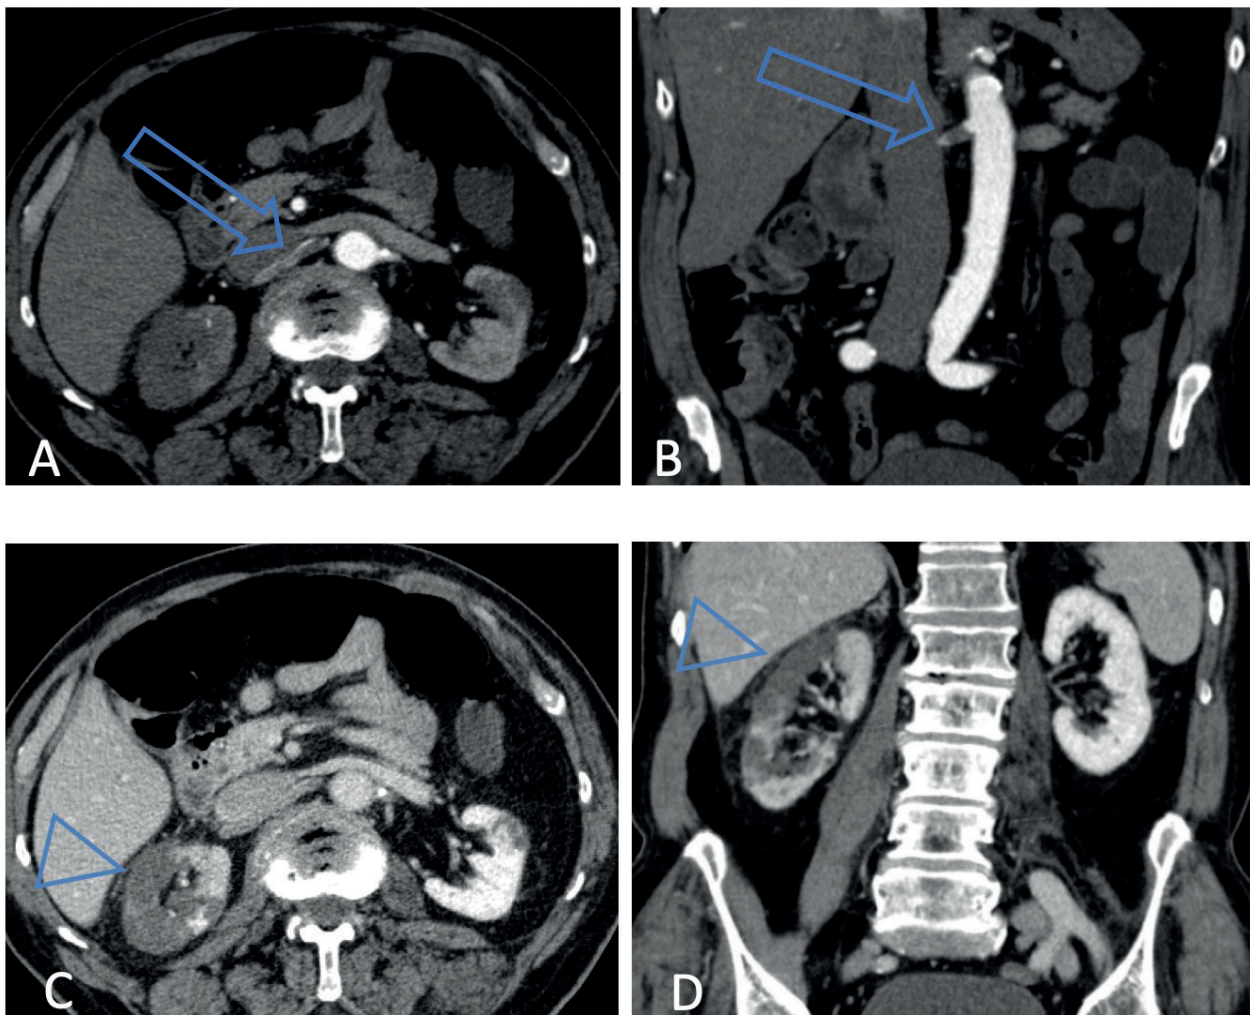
CTA of the abdomen at admission. Arterial phase showing thrombosis of the proximal branch of the right renal artery in axial (A) and coronal (B) multiplanar reconstruction (arrows). Venous phase axial (C) and coronal (D) multiplanar reconstruction showing multiples ischemic foci in the right kidney (arrowheads).
